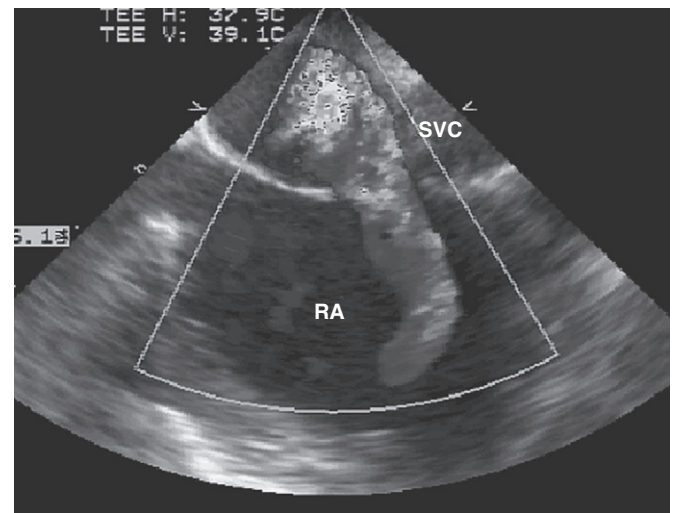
Sinus venosus atrial septal defect on sagittal scan by TEE with left-to-right shunting by color Doppler. RA, Right atrium; SVC, superior vena cava.
